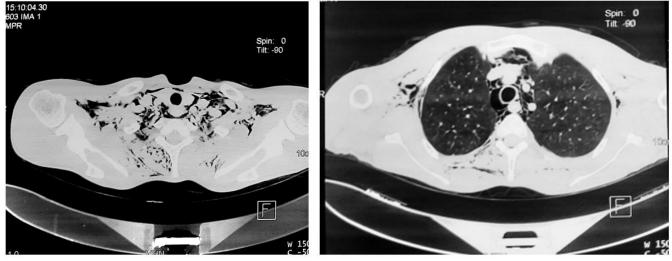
CT scan images showing pneumomediastinum and subcutaneous emphysema
